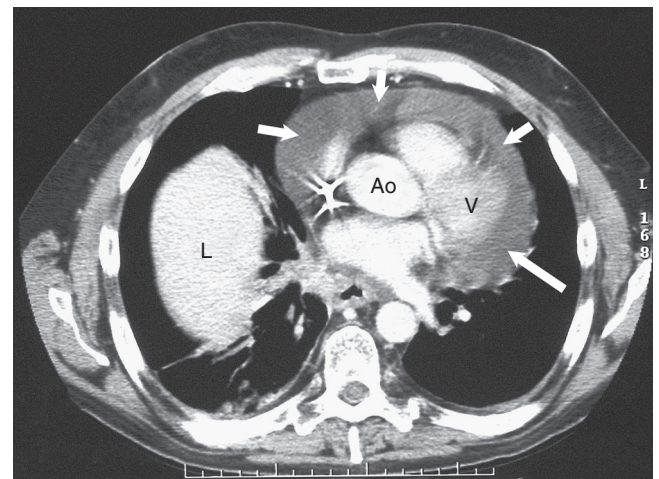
■ CT scan shows moderately large pericardial effusion (arrows). Ao, Aortic root; L, liver dome; V, atrioventricular junction with adjacent pulmonary outflow tract.
